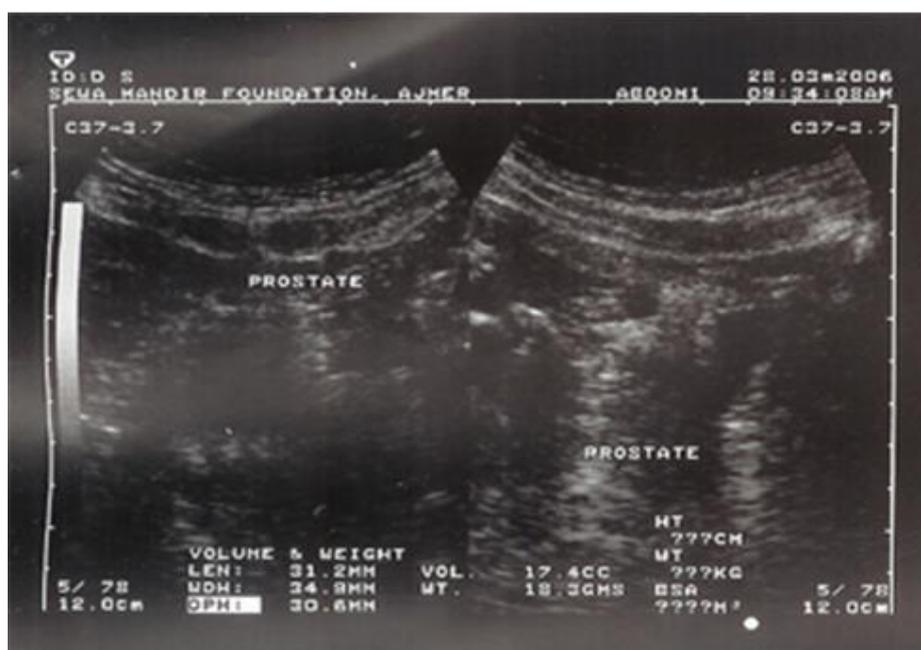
Sonography report after treatment (28.03.2006) showing Prostate measuring 31mm x 35mm x 31mm in size and weight 18.3 gms. Prostate volume is 17.4 cc
